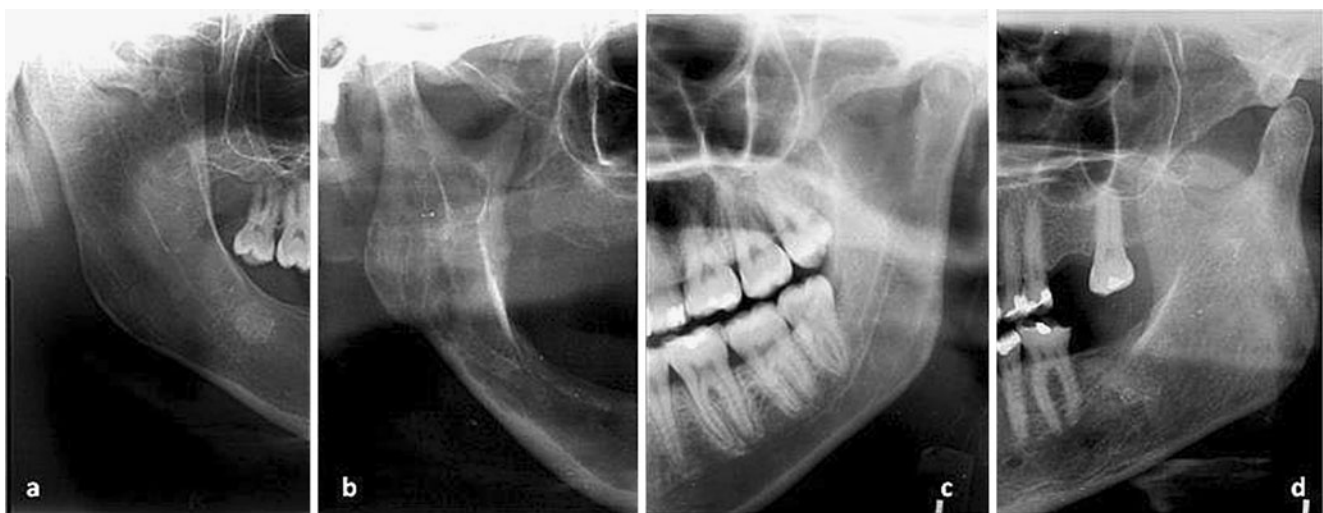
Cropped panoramic radiographs displaying radiographic features observed in sickle cell disease patients: a. Radiopaque areas in jaw bones. b. Increased trabecular bone spacing. c. Significant
